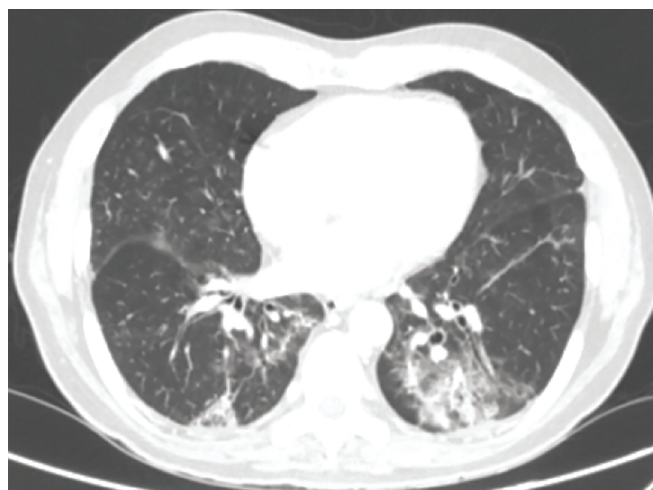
Computed tomography scan section of the lower thorax showing the residual ground-glass opacities and lung changes suggestive of fibrosis
